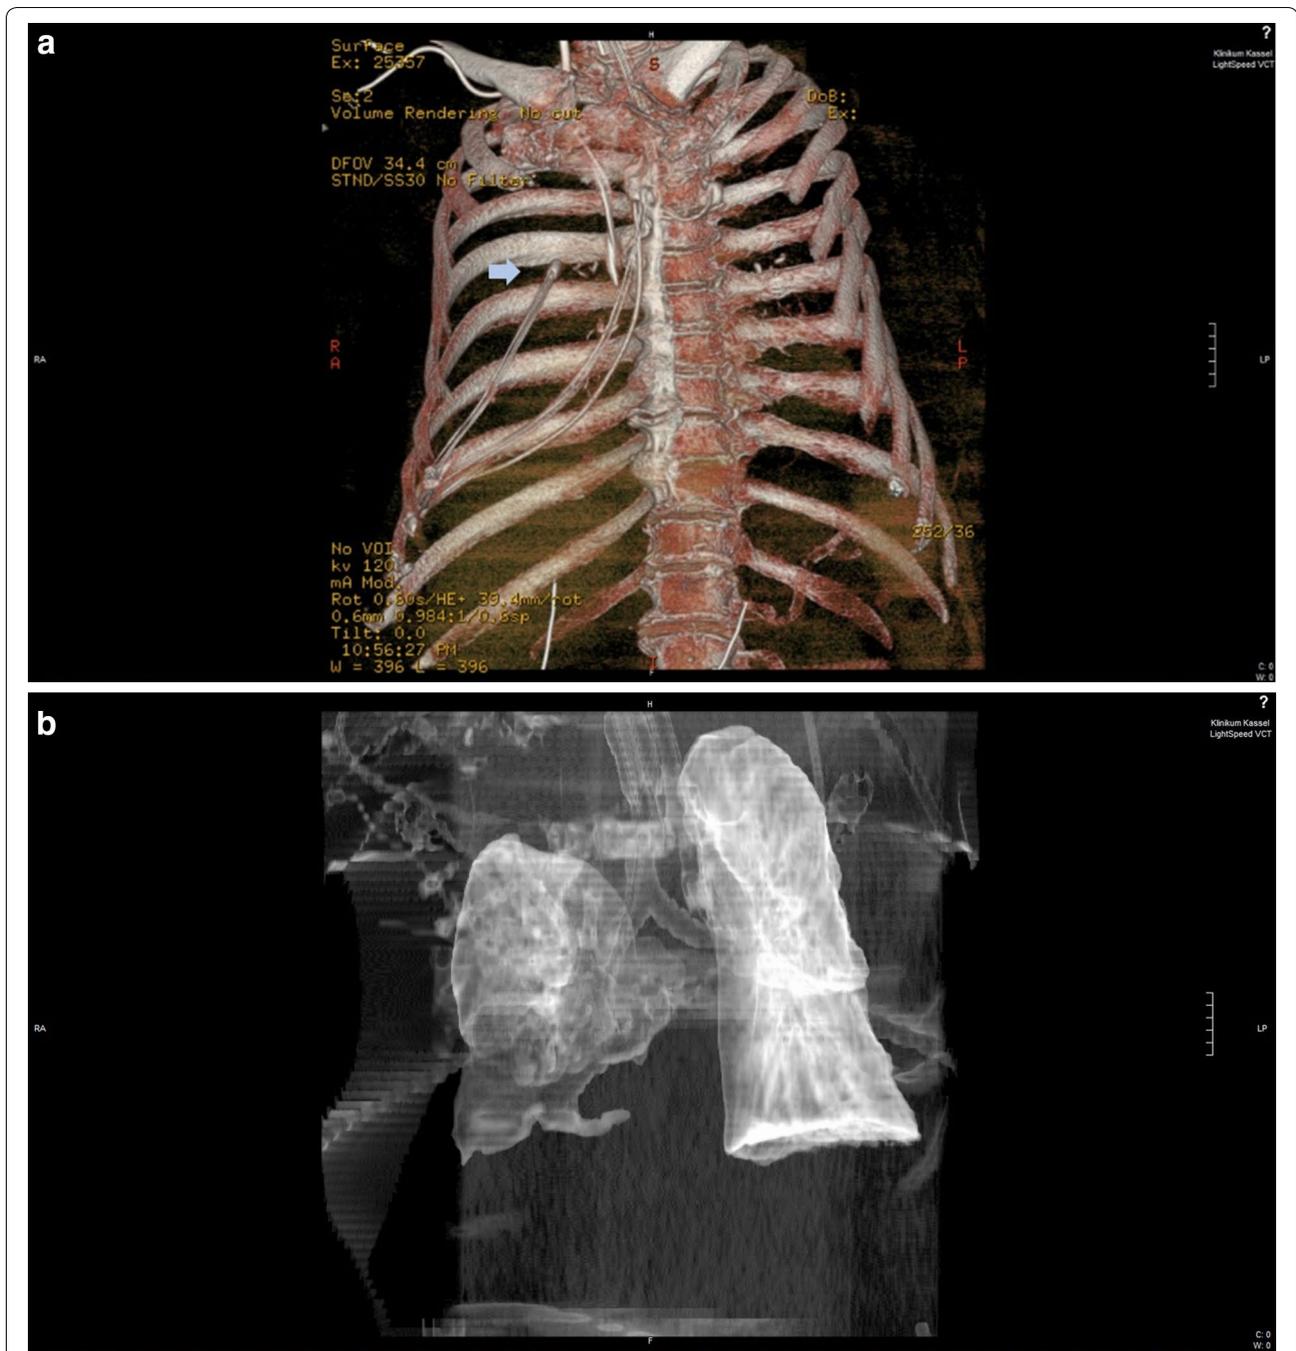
a 3D-reconstructed image of a chest computed tomography, demonstrated the endpoint of the nasogastric tube into the right pleura (*arrow*). b 3D-reconstructed image of a chest computed tomography, showing the massive right lung parenchyma damage
